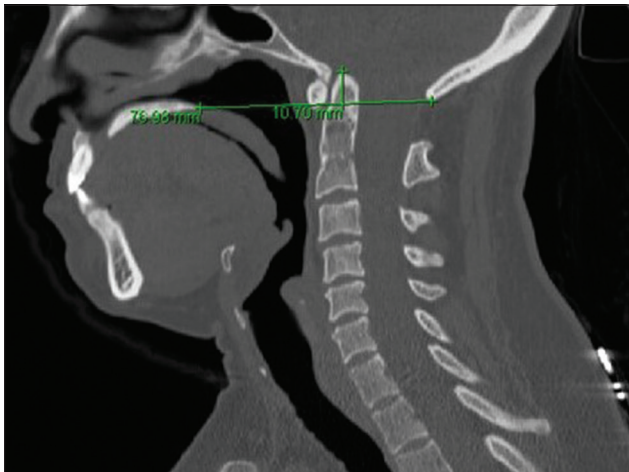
Preoperative radiograph demonstrating the Chamberlain line suggestive of basilar invagination.
